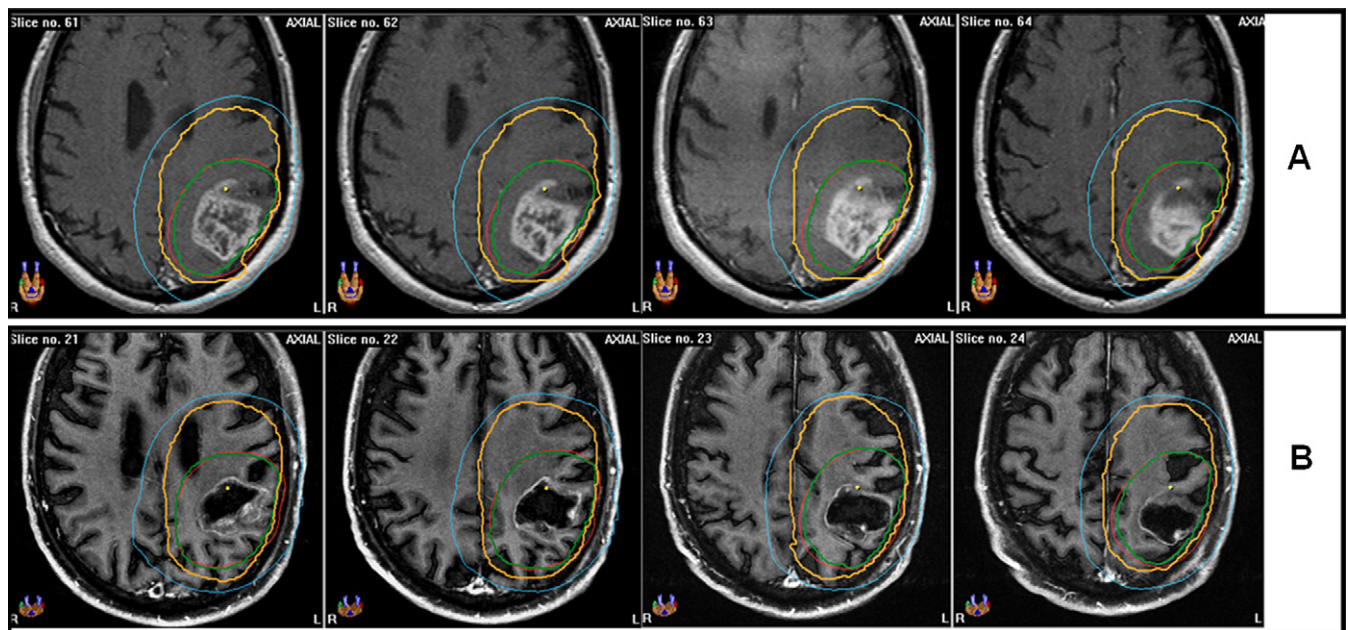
T₁-weighted contrast-enhanced magnetic resonance image from a patient with needle biopsy-proven glioblastoma. Patient declined craniotomy and was treated at Level 4 (60 Gy in 6-Gy fractions within 2 weeks). Planning target volumes 1 (PTV1; dark green) and 2 (PTV2; brown) outlined; 30-Gy (red) and 60-Gy (cyan) isodose lines also shown. (A) Treatment planning magnetic resonance image with 3-mm slice thickness. (B) Follow-up magnetic resonance image with 5-mm slice thickness performed 3 months after radiotherapy.
